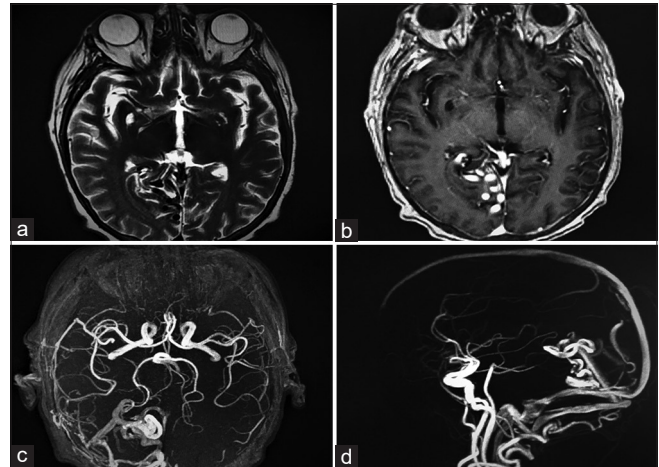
MRI where we observed a serpiginous path of the arteriovenous malformation at the parieto-occipital region. (a) Axial T2-weighted sequence. (b) Axial T2-FLAIR sequence. (c) Axial 3D TOF. (d) Sagittal 3D TOF.
